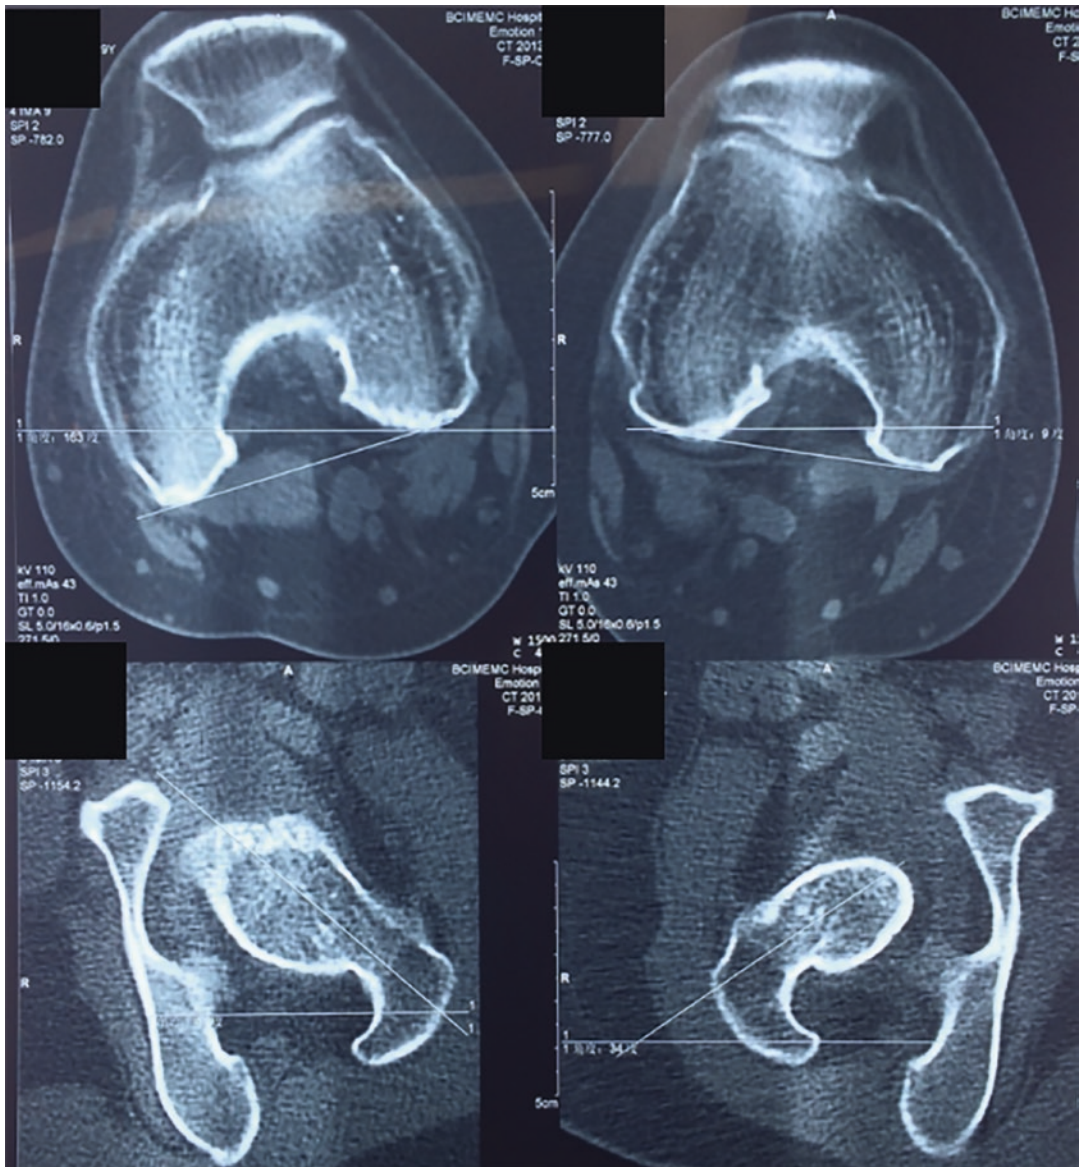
The femoral anteversion angle needs to be calculated before operation, usually it can be preliminarily calculated by CT image measurement
